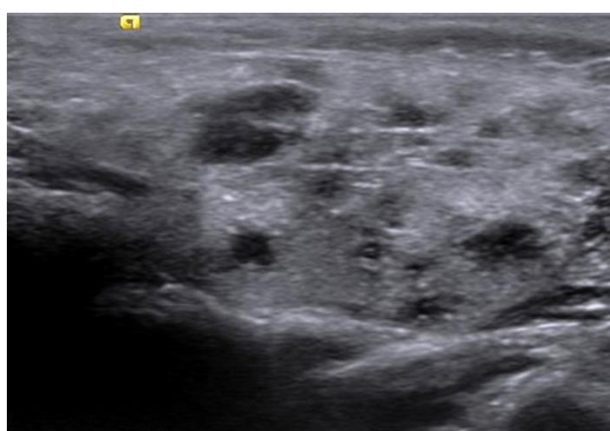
(C): Sonography of parotid gland showing multiple hypoechoic areas with enlarged gland.
